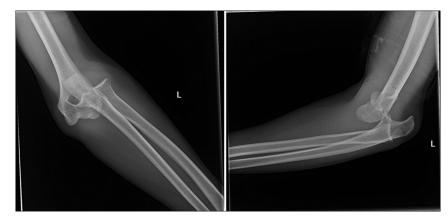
X-ray Anteroposterior and lateral views showing posterolateral elbow dislocation
